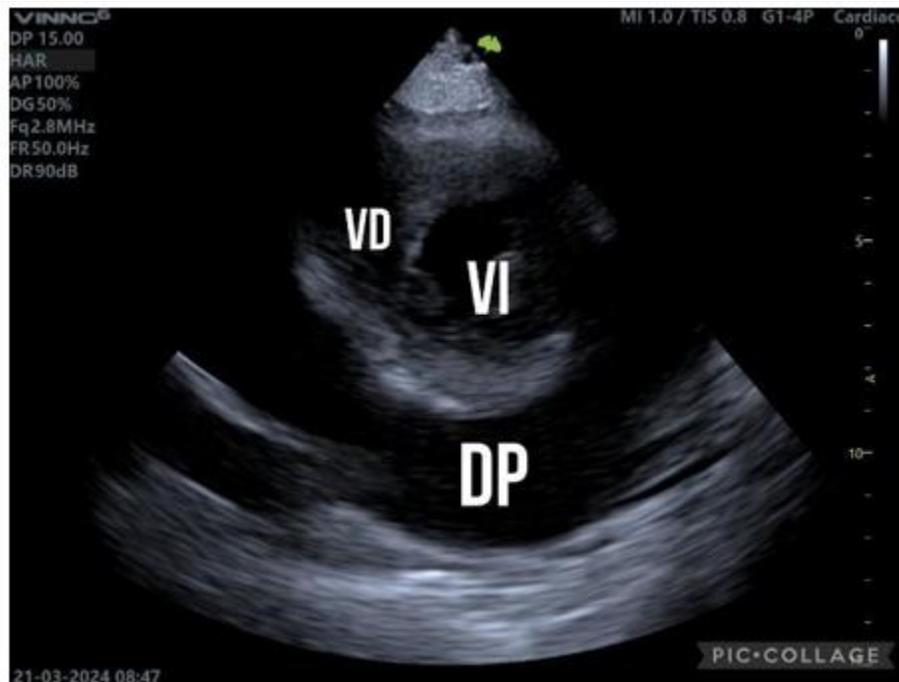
Parasternal short-axis view with evidence of massive pericardial effusion. DP: Pericardial Effusion, LV: Left Ventricle, and RV: Right Ventricle
